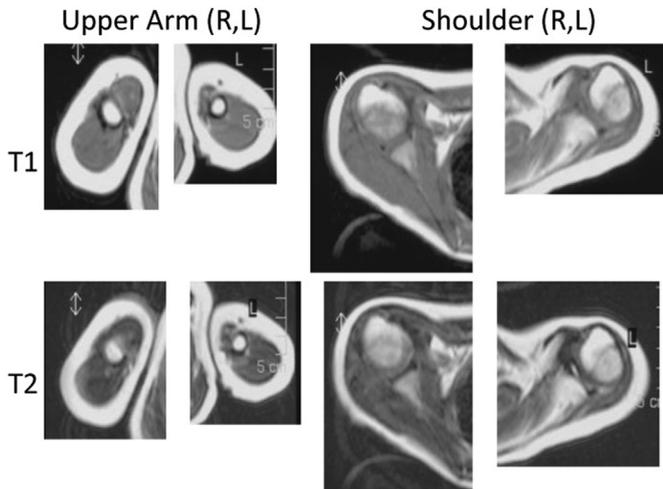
MRI of both upper arms and shoulders 3 years and 10 months after denervation showing extreme atrophy of the left deltoid, infraspinatus and biceps muscles. These muscles have the same intensity in both T1W and T2W as the healthy side.
